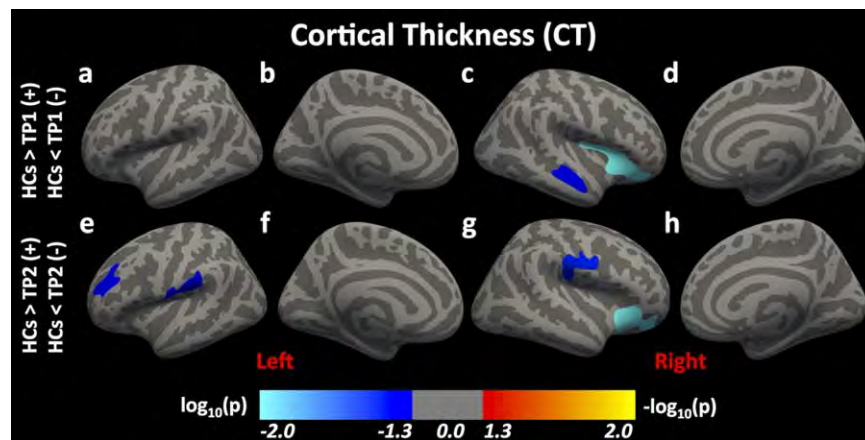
Differences in cortical thickness (CT) following mTBI. Here, we report significant differences in CT between HCs and individuals with mTBI at time-points (TPs) 1 and 2 [Color figure can be viewed at wileyonlinelibrary.com]
